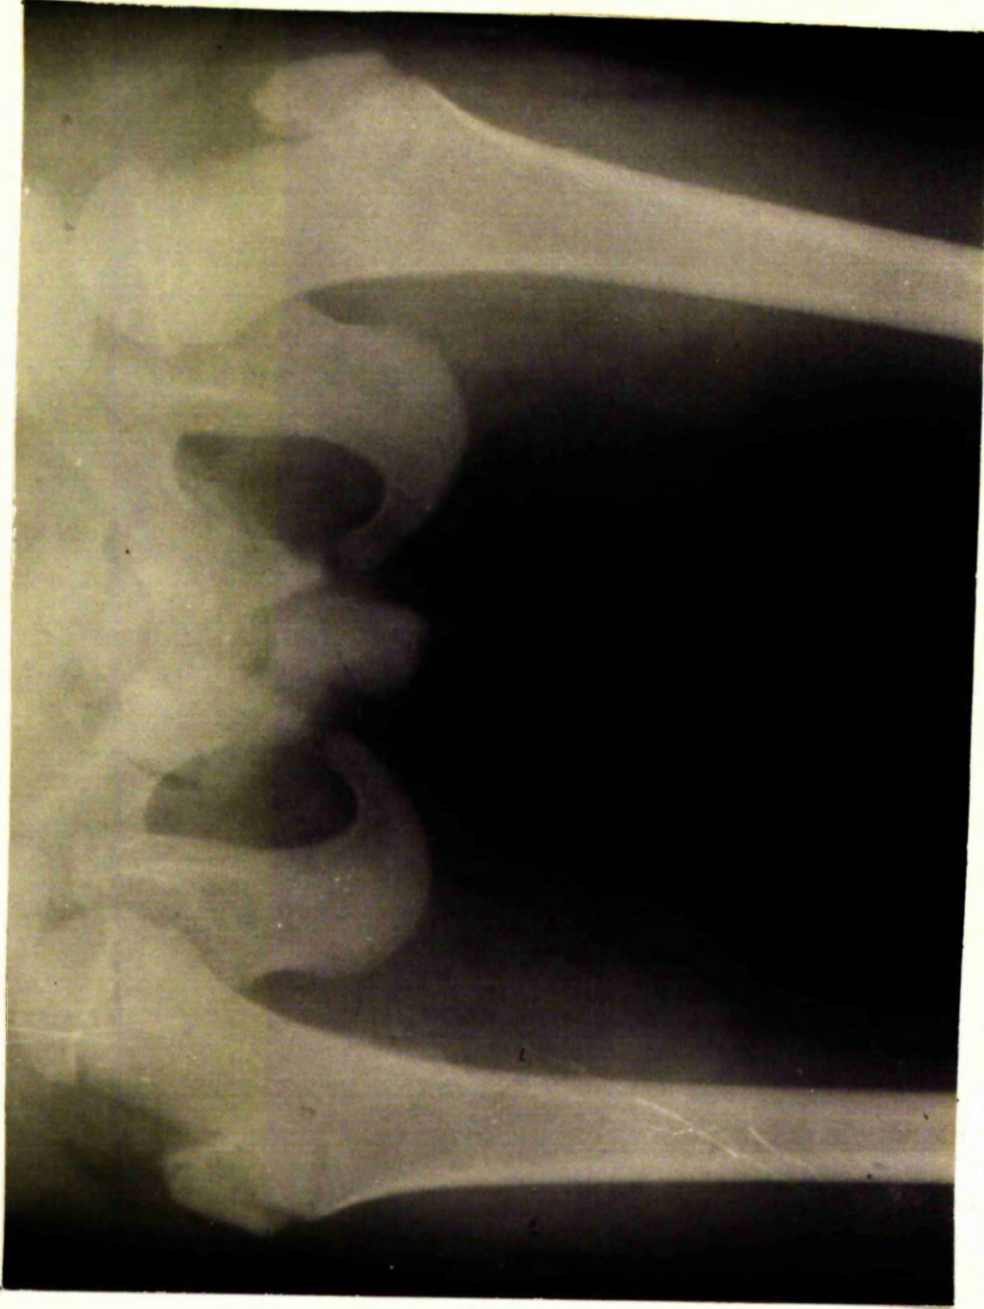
X-ray of femora and pelvis showing bilateral coxa valga.
